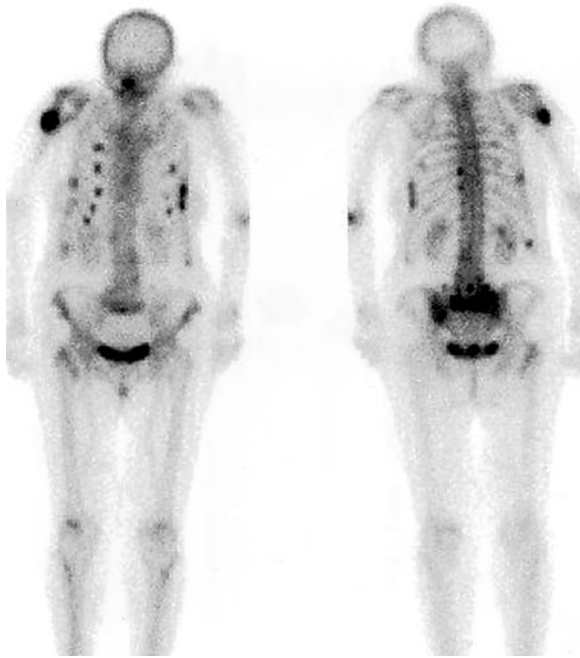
Extensive osseous metastases from lung carcinoma. Anterior (left) and posterior (right) whole-body bone scintigrams show multiple, randomly distributed foci of abnormal radiotracer uptake. The foci vary in size and intensity.
